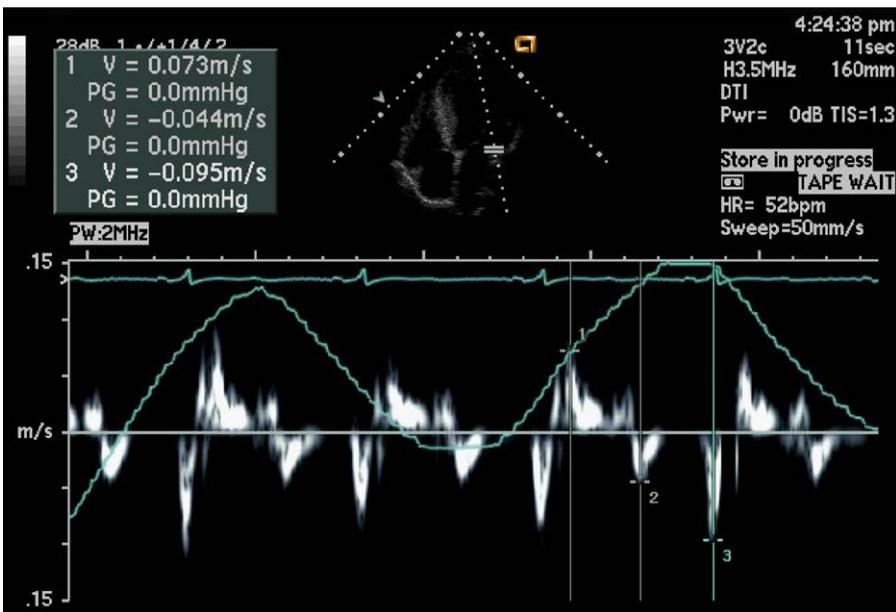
Measurement of tissue Doppler basal lateral myocardial velocities in a patient who has dilated cardiomyopathy: Early diastolic velocity ( $E_M$ )=4.4 cm/s, indicating abnormal LV relaxation. Combining this index with early left ventricular filling pulsed Doppler velocity ( $E=80$  cm/s) shown in Fig. 7 yields a  $E/E_M$  ratio of 18, equivalent to an estimated mean left atrial pressure of 24 mm Hg.
